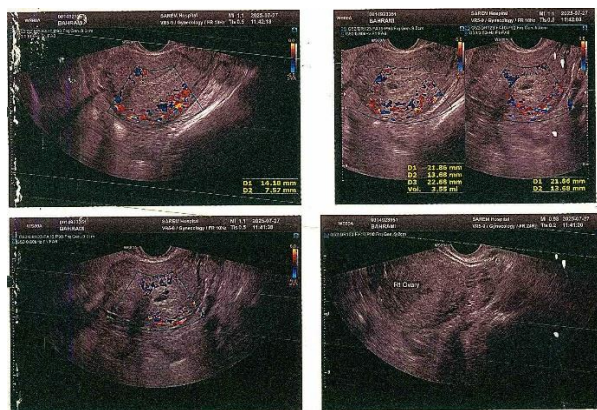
Color Doppler image of the same lesion in the uterine cornual region, showing a peripheral hypervascular pattern (*ring of fire sign*), a characteristic feature of ectopic pregnancy.
